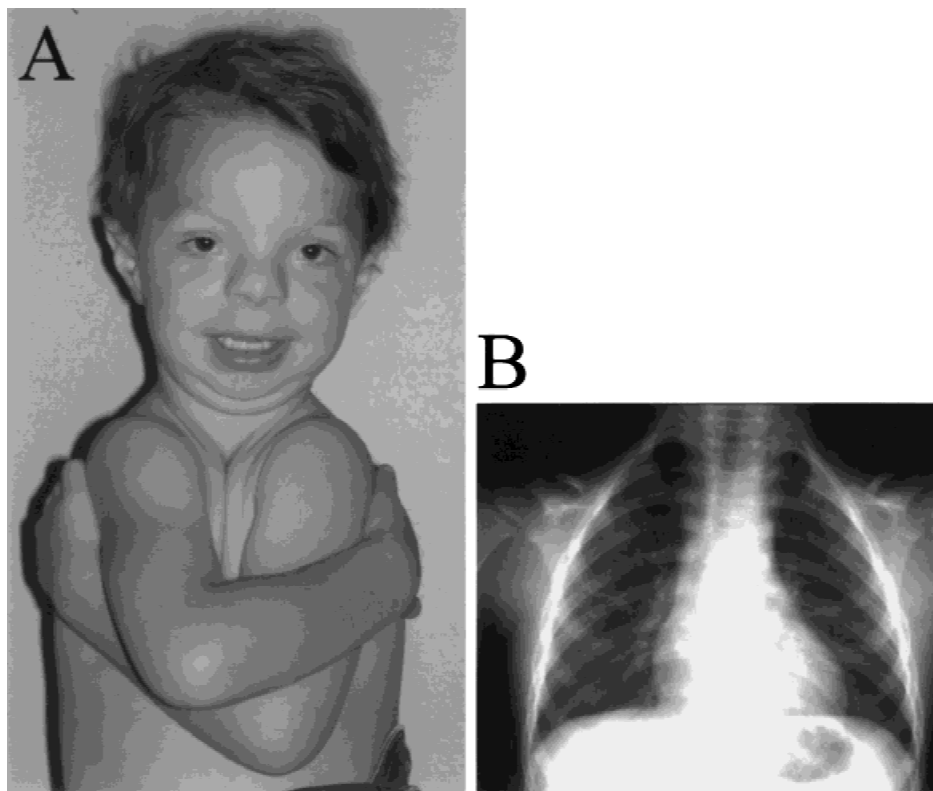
The clavicular hypoplasia as documented clinically by hypermobile shoulders (A) and on chest radiograph (B) at age 4 years is shown. Note the severely hypoplastic clavicles visible above the scapulae bilaterally.
